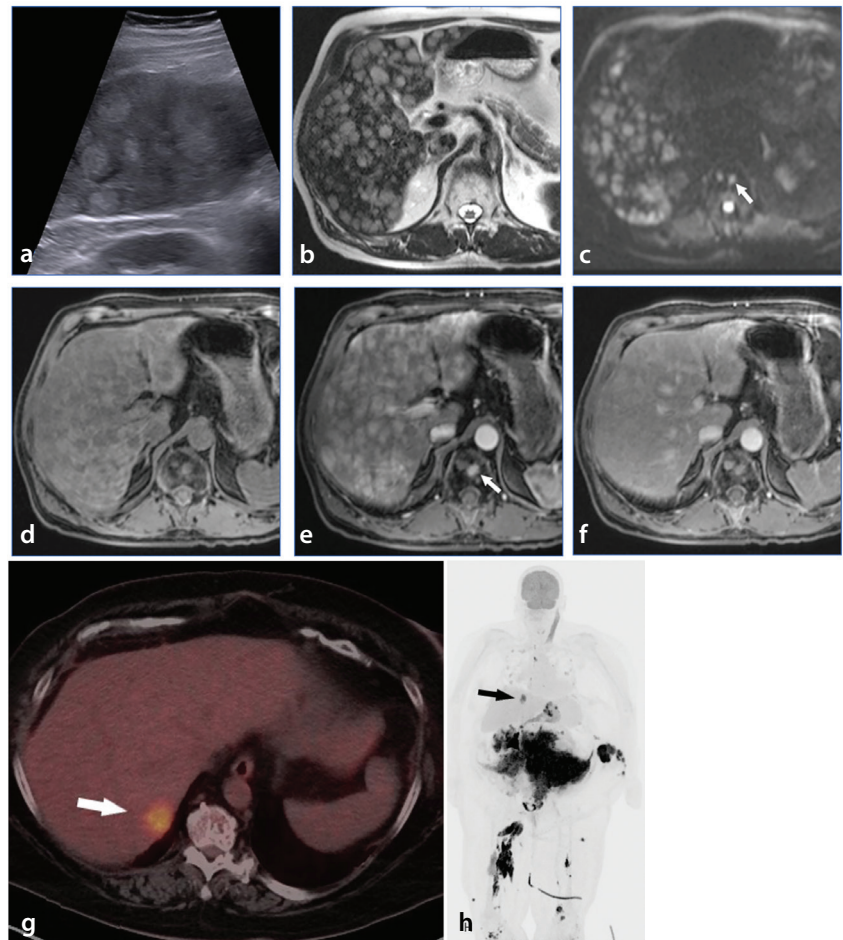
Multiple myeloma. Transabdominal ultrasonography (a) shows multiple hyperechoic liver lesions surrounded by a zone of low echogenicity resulting in target appearance. Axial T2-weighted imaging (b), axial diffusion-weighted imaging (DWI) (c), axial T1-weighted imaging (d), and post-gadolinium T1-weighted imaging with fat suppression during the arterial (e) and delayed (f) phases show numerous liver lesions demonstrating high T2 and low T1 signal intensity, with diffusion restriction on DWI. The lesions show intense enhancement in the arterial phase and are not visible in the delayed phase of contrast enhancement. A fluorodeoxyglucose-positron emission tomography/computed tomography scan (g, h) of a case of extramedullary multiple myeloma shows uptake (white and black arrows).
